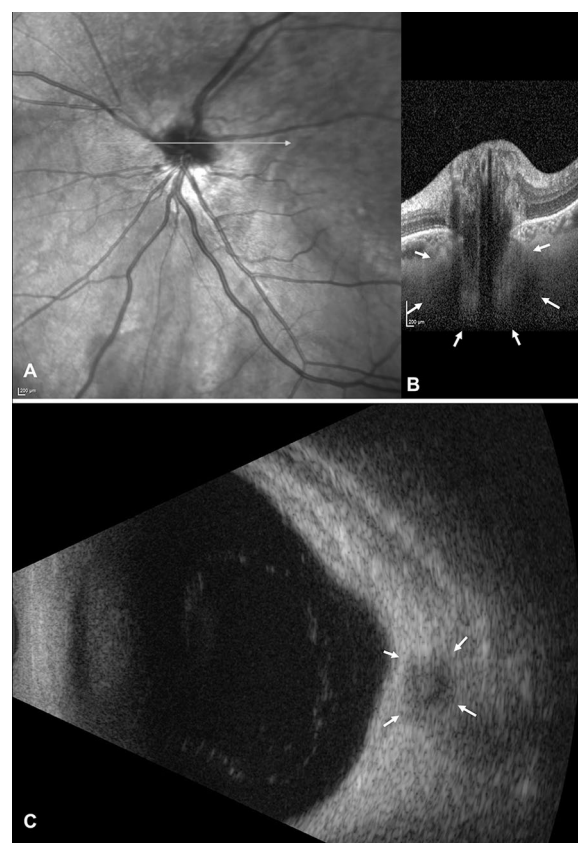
a, b Infrared reflectance image of the optic nerve head (ONH) and of the peripapillary retina (a) and corresponding structural spectral-domain ocular coherence tomography (OCT) B-scan crossing the ONH of the left eye (b). A tilted disk appearance is denoted, and a well-delimited, approximately round structure beneath the ONH is observable (white arrows). c Ultrasonography showed a slight elevation of the ONH, along with an hypochogenic round structure below the optic disk (white arrows)
